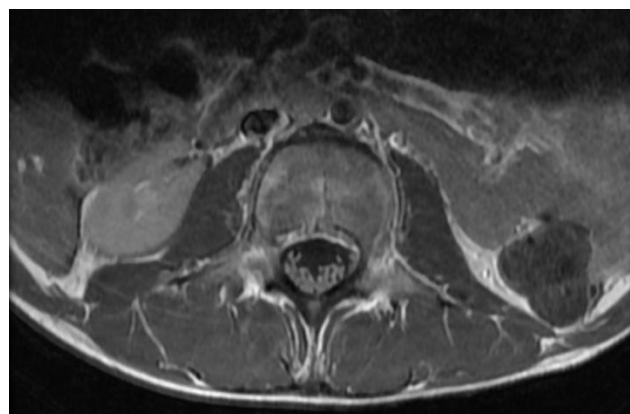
MRI Spine Axial T1 with contrast showing cauda equina nerve root enhancement.
